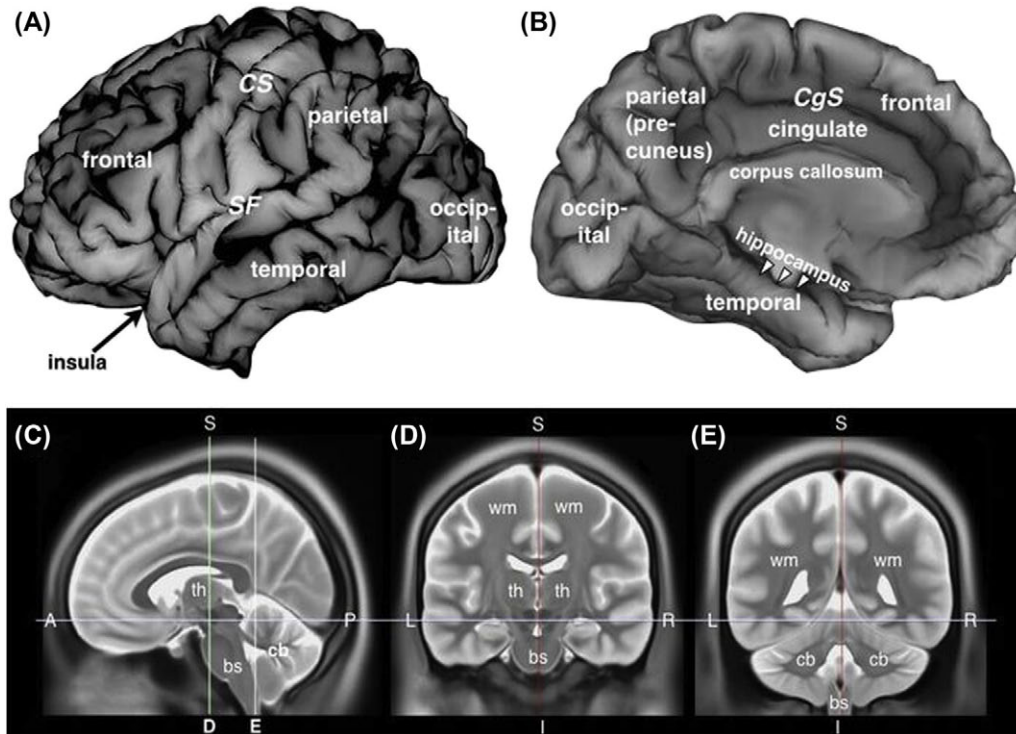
Human brain morphology. (A, B) The location of the major lobes are shown in lateral (A) and medial (B) views of the left cerebral hemisphere. The central sulcus (CS) separates the frontal and parietal lobes; the Sylvian fissure (SF) separates the temporal lobe from the frontal and parietal lobes. The insula is a region of limbic cortex buried within the SF. The cingulate sulcus (CgS) separates the cingulate cortex from the frontal and parietal cortex. (C–E) T2-weighted MRI images showing the relationship of the cerebral hemispheres to deep structures, including the thalamus (th), cerebellum (cb), and brainstem (bs). The section in C is in a parasagittal plane, with anterior (A) to the left. D and E are coronal sections; their locations are marked in C. In T2-weighted images, the cortical gray matter appears as a light rim surrounding the darker white matter (wm). Images were captured from the Human Connectome Project (HCP) datasets using HCP Workbench software (Van Essen et al., 2013). Additional abbreviations: *I*, inferior; *L*, left; *P*, posterior; *R*, right.
